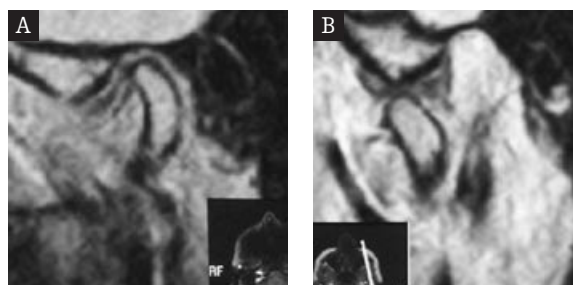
MRI of the TMJ. Mild anterior disc displacement with reduction during the jaw opening phase. I° in Wilkes score.
